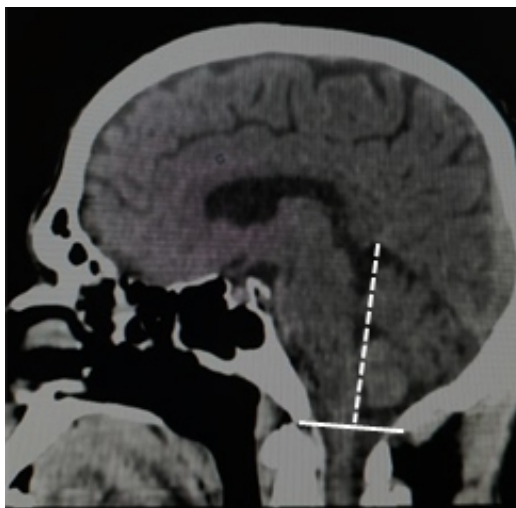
Sagittal reconstructed CT image of the brain demonstrating
